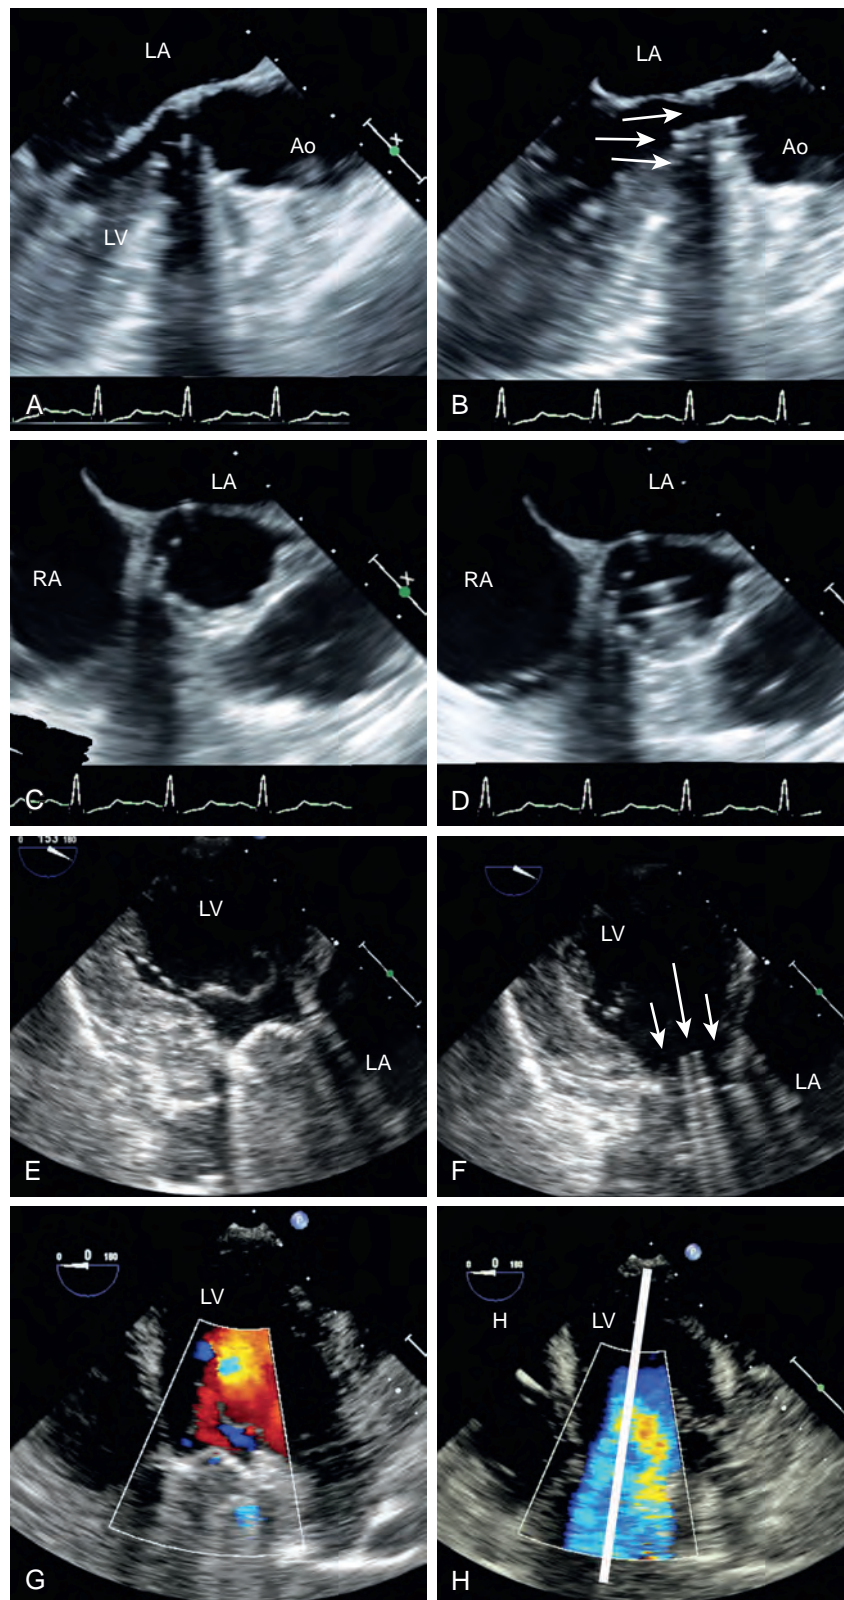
Aortic valve replacement: mechanical valve. Normally functioning bileaflet mechanical valve in the aortic position. Left-sided figures were obtained during diastole and right-sided figures during systole. (A–D) Midesophageal long (A and B) and short (C and D) two-dimensional views of the valve. Normal leaflet mobility is noted by seeing the edges of each leaflet during ventricular systole as seen in (B) and (D). (E–H) Transgastric imaging complements transesophageal imaging. Color Doppler imaging shows (G) insignificant insufficiency and (H) normal Doppler flow during systole. Ao, Aorta; LA, left atrium; LV, left ventricle; RA, right atrium.
